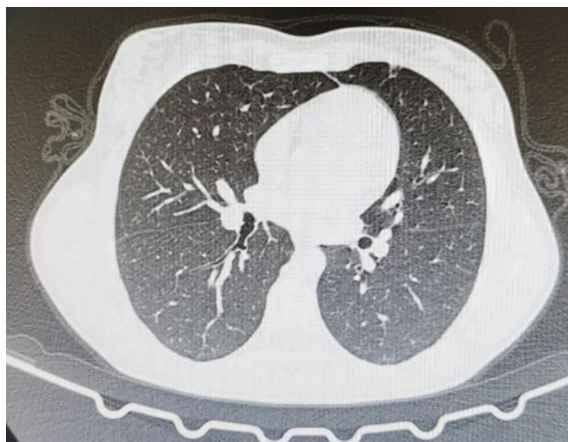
Chest spiral CT for the patient on Dec 9th.
